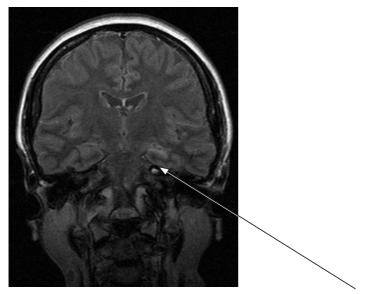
MRI T1. Mesial temporal sclerosis. Sclerosis & contracted hippocampus (left).
